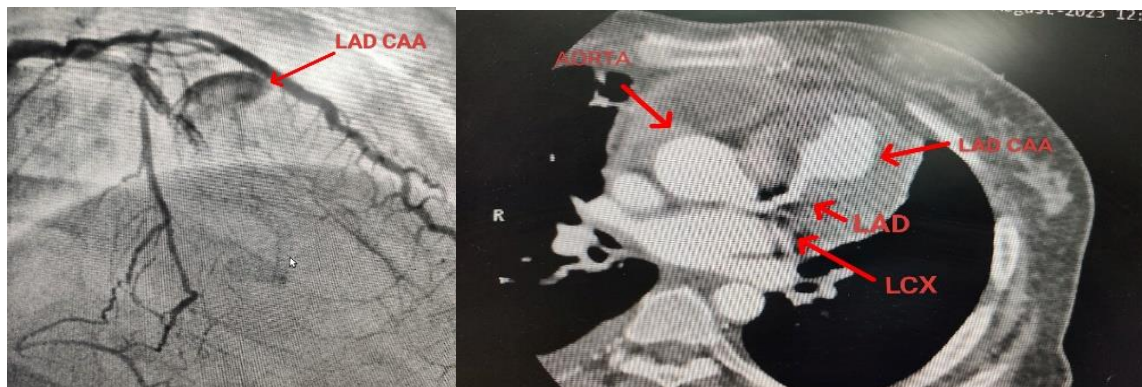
Fluoroscopy images of Coronary angiogram and CT angiography show aneurysmal dilatation of LAD
